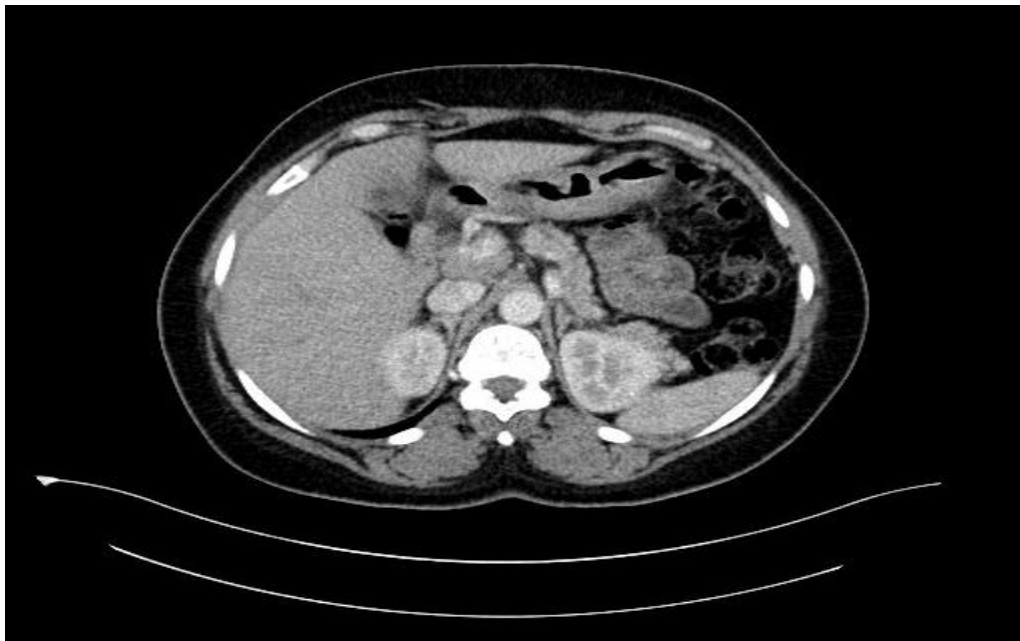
CT scan showing a tissular process of the head of pancreas measuring 25x20 mm.
